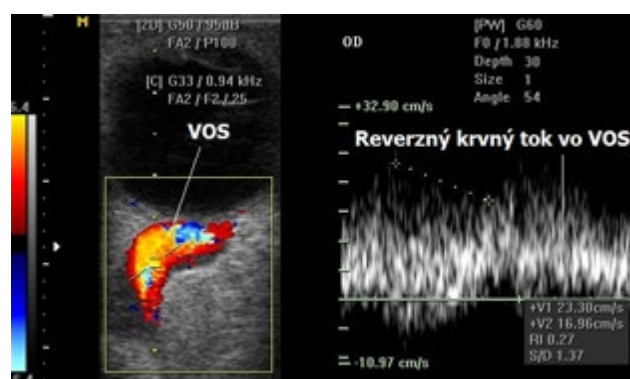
Colour display of retrograde flow and dilation of VOS upon direct carotid-cavernous fistula with the aid of Colour Doppler ultrasonography. Left image: Under physiological conditions the venous blood flow is coded blue, and the arterial flow red. In the case of carotid-cavernous fistula, retrograde blood flow ensues, meaning a change of the colour coding from blue to red. Right image: recording of spectral analysis of retrograde blood flow of VOS – reverse blood flow in VOS
